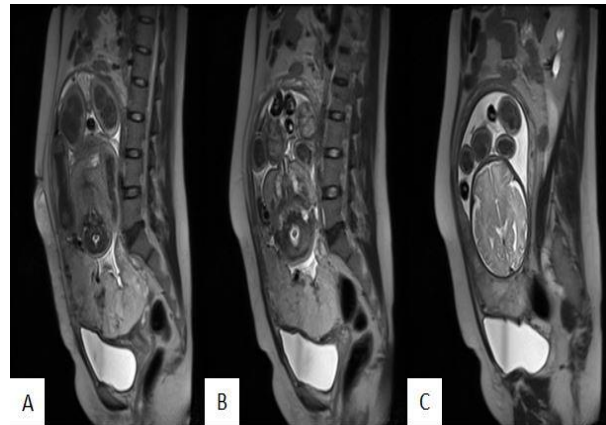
MRI Pelvis sagittal T2WI sequence showing complete placenta previa with multiple linear hypointense bands (A), urinary bladder wall thinning with tenting (B) and flow voids in urinary bladder wall suggestive of bladder invasion (C).
